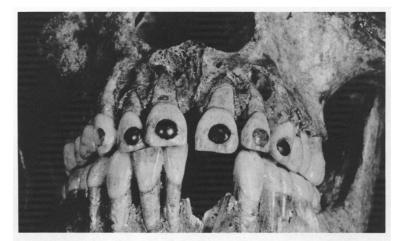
The four dark inlays are of hematite; one is lost from the right cuspid, and one in the left lateral incisor is replaced with a jadeite inlay. Maya skull now in the National Museum of Anthropology of Mexico. The X-ray shows a periapical infection in the lateral incisor, probably produced by a lesion during the preparation of the cavity for the inlay.
